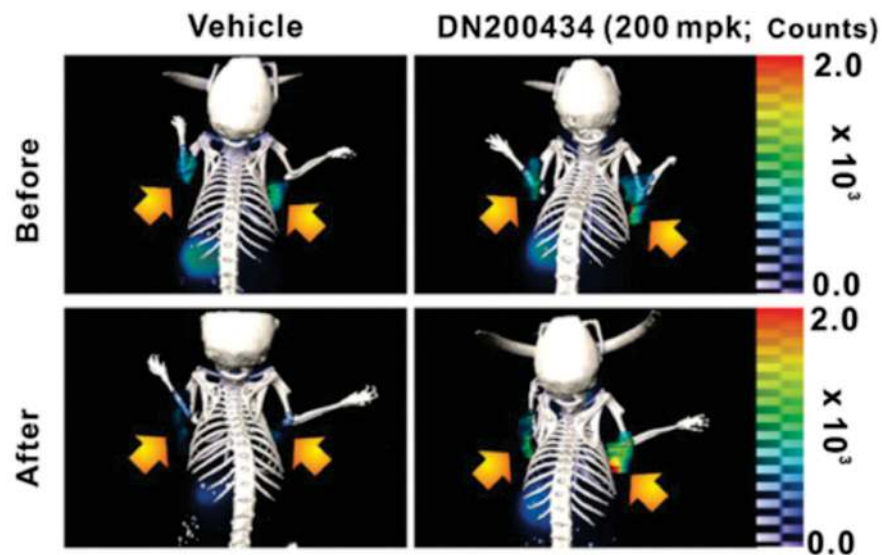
[^{124}I]NaI-PET/CT demonstrates enhanced iodine uptake in CAL62 ATC tumor after treatment with DN200434. The arrows indicate the ATC tumor. Reproduced with permission from [40], copyright 2019 American Association for Cancer Research.
